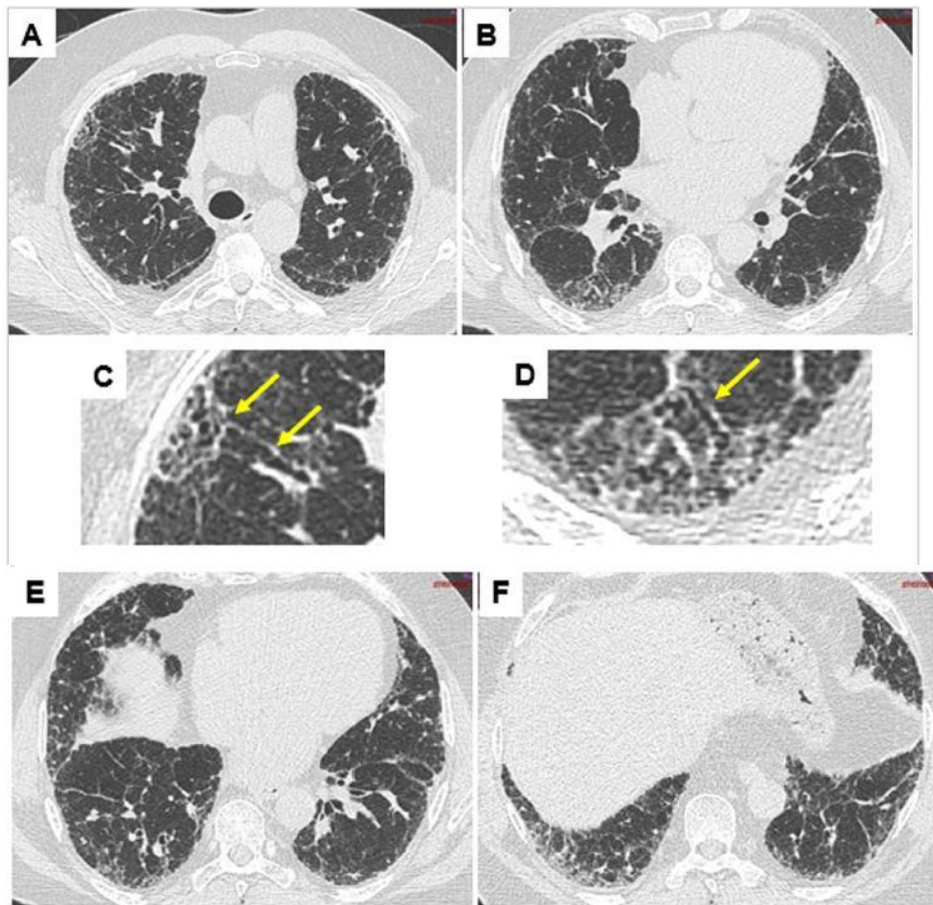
Probable usual interstitial pneumonia pattern on the CT scan. Presence of predominantly subpleural and basal reticular opacities, traction peripheral bronchiolectasis, in the absence of any sign incompatible with this diagnosis, but without honeycombing. C, D: enlargement of A and B showing traction peripheral bronchiolectasis (arrows).
